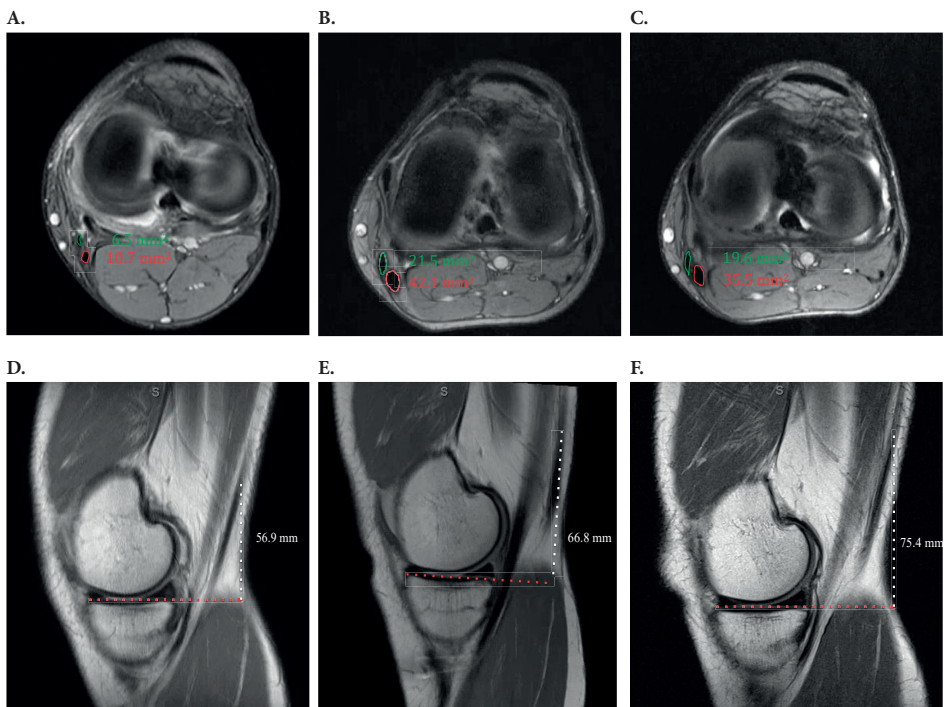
Representative MR images of same patient.
